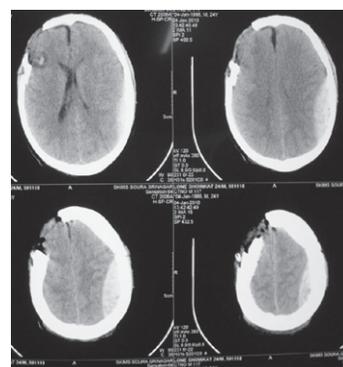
CT head in immediate post operative period which shows EDH in left temporoparietal region and complete evacuation of EDH in right frontotemporal region and craniotomy site.
